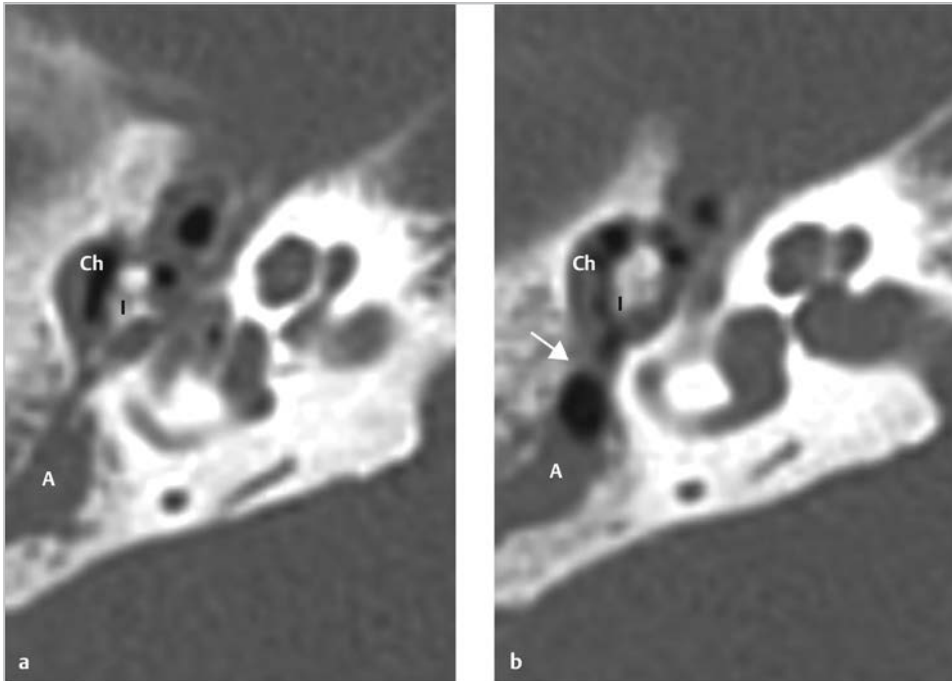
A case of cholesteatoma to which extended indication of modified Bondy technique is applied is shown. (a) The axial CT showed presence of cholesteatoma (Ch) in the attic with nearly intact ossicular chain. The posterior limit of the cholesteatoma seems to be located at the level of the aditus ad antrum (*arrow*), and (b) the antrum seems to be ventilated to some extent. Soft tissue density medially to the intact ossicular chain is indistinguishable from middle ear effusion. A, antrum; I, incus.
